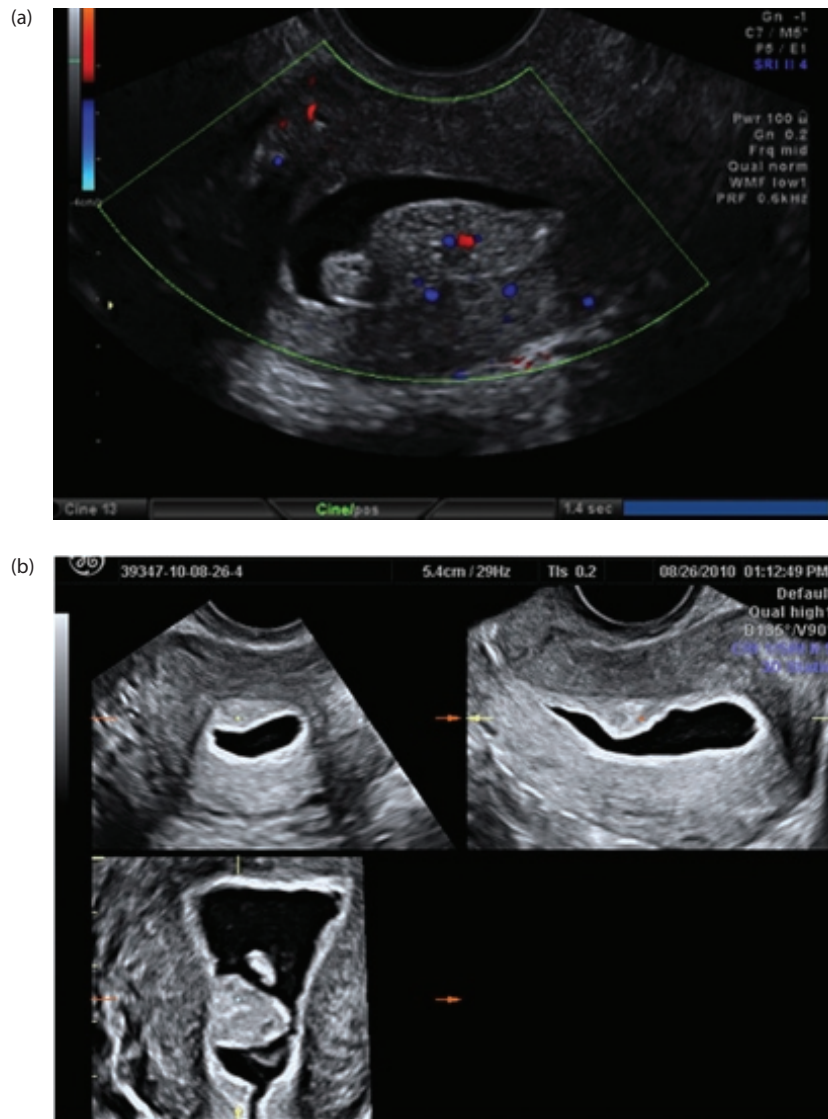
Saline sonogram of uterine polyp. (a) Color Doppler showing feeding vessel into polyp; (b) Pre-operative evaluation—multiplanar view of the uterine polyp.
